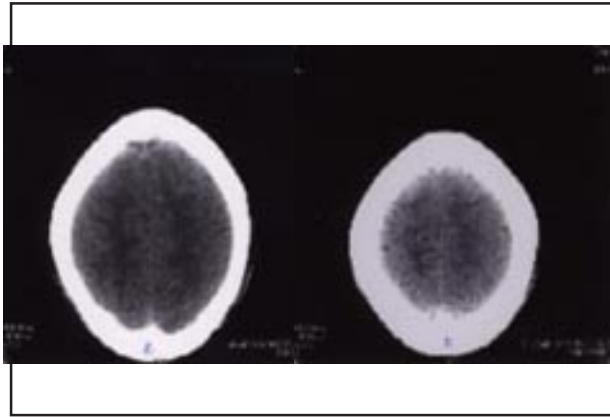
a, b: Follow-up non-contrast Cranial CT scan showing resolving hypodensities.
